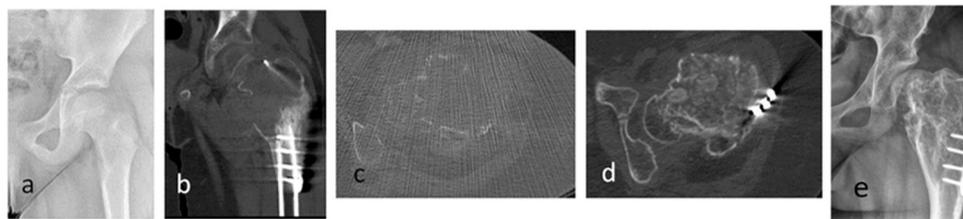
Patient #4 a: Radiograph of the hip at diagnosis; b: Computed tomography, coronal view after curettage, defect filling, and plate fixation; c: Computed tomography, axial view showing a recurrence despite the two previous surgical procedures; d: Computed tomography 6 months after denosumab initiation showing reconstitution of the cortex peripherally and cortico-medullary dedifferentiation centrally, with no change in size (RECIST); e: Hip radiograph at last follow-up 32 months after denosumab initiation.
